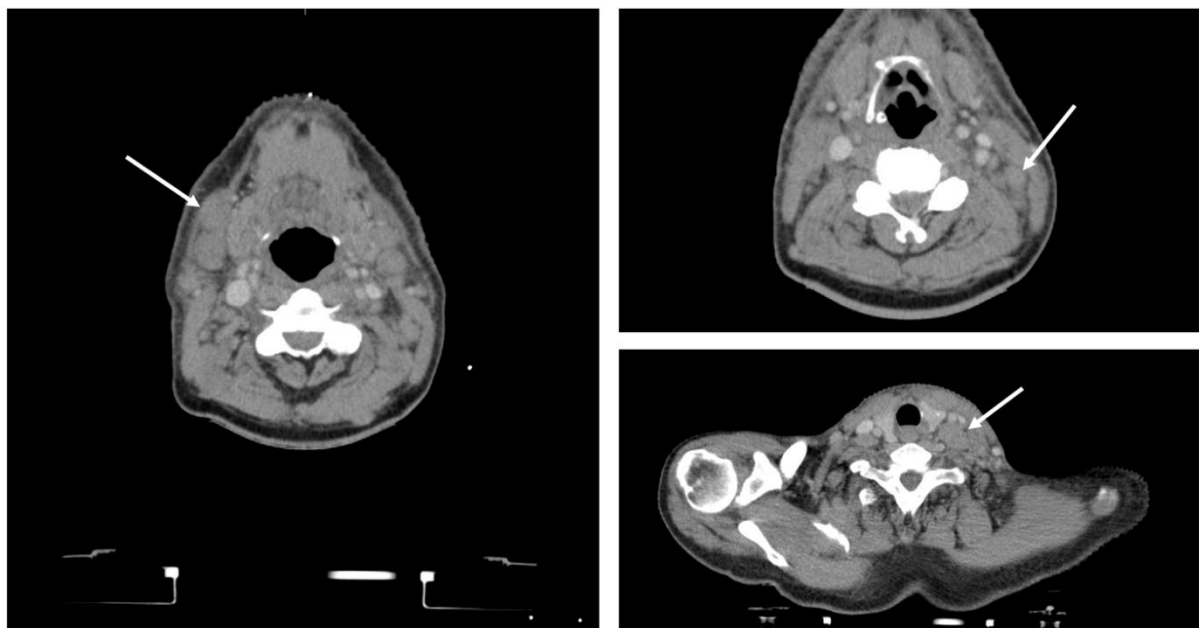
Contrast-enhanced CT images showing locoregional relapse of nasopharyngeal DLBCL
